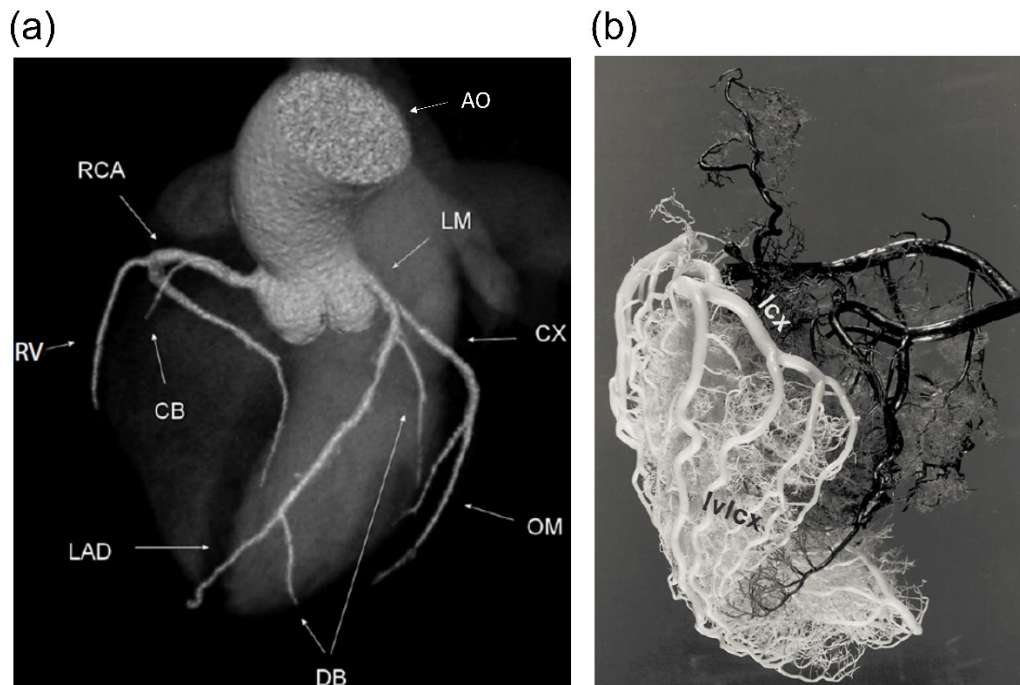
(a) Epicardial coronary anatomy as obtained from 3D Computed Tomography (adapted with permission from [52]). AO aorta, LM left main coronary artery, CX left circumflex artery, OM obtuse marginal branch, LAD left anterior descending artery, DB diagonal branch, RCA right coronary artery, RV right ventricular branch, CB conus branch. (b) Cast of the human coronary circulation; the left circulation is displayed in white and the right circulation in black (adapted with permission from [19]).
